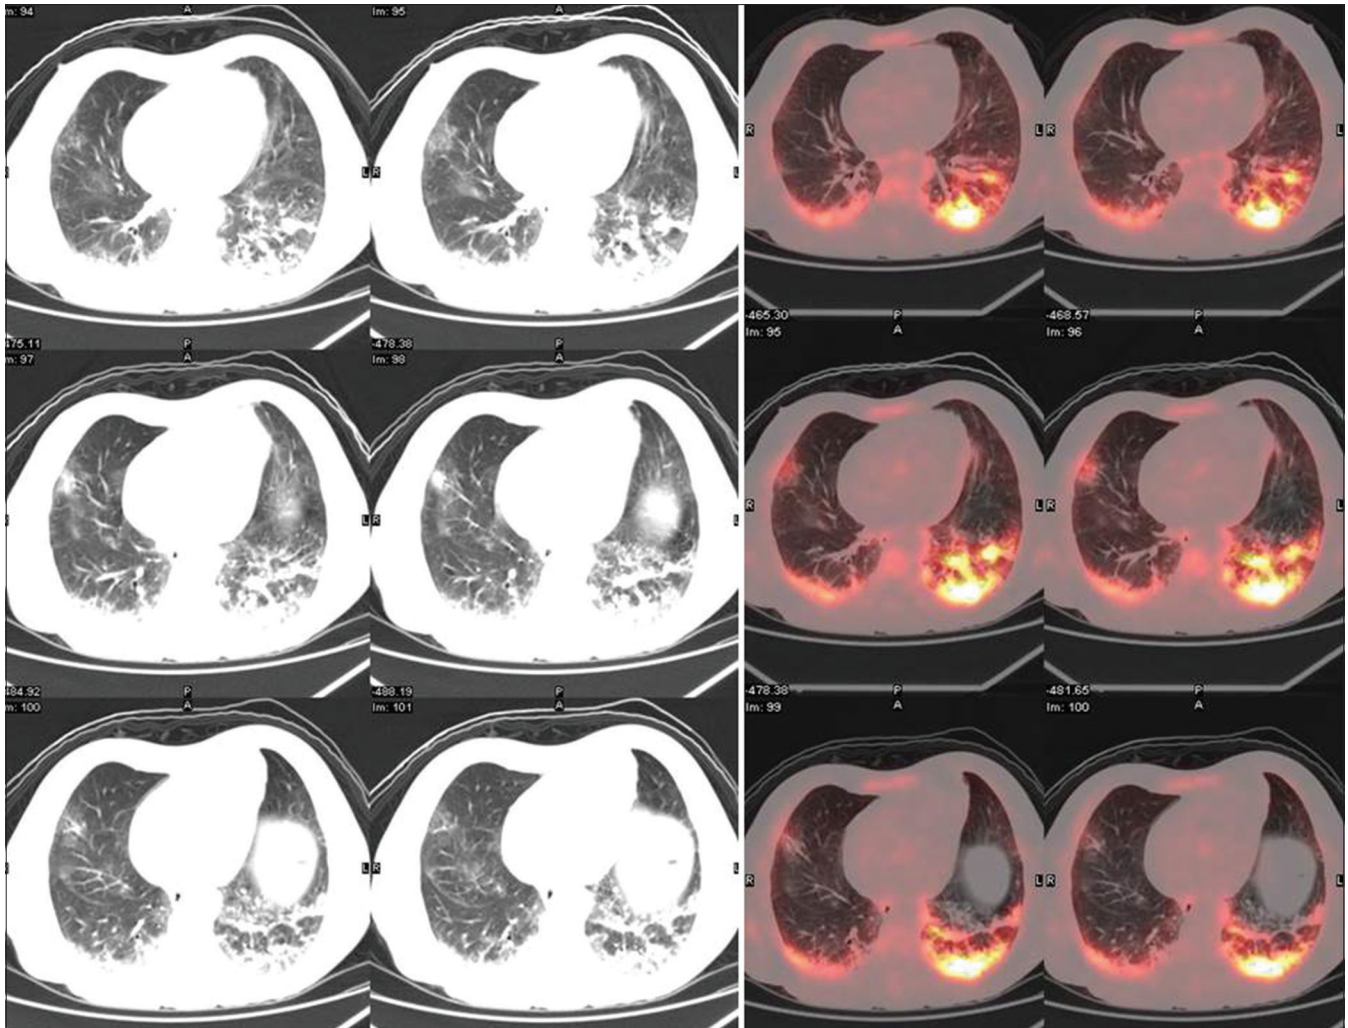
CT and axial fused ^{18}F -FDG PET/CT images of the lungs: Heterogeneous ^{18}F -FDG uptake predominantly along subpleural posterior and posterobasal regions in both lungs with peripheral subpleural ground glass opacities with reticular inter and intralobular septal thickening with traction bronchiolectatic changes
